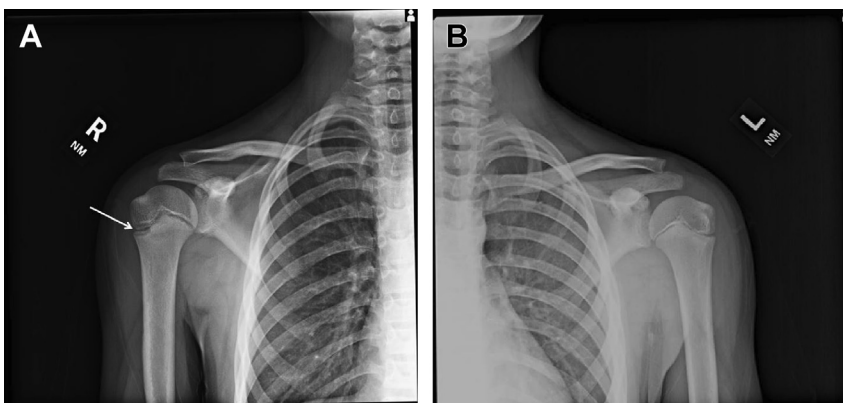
(A) A 12-year-old boy with shoulder pain at the beginning of the baseball season. Radiograph of shoulder of throwing arm at presentation. White arrow shows widening of the proximal humeral physis. (B) Left shoulder radiograph taken for comparison at initial presentation.
